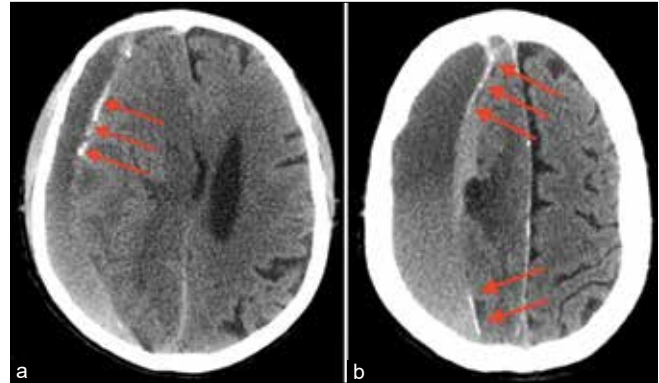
Head computed tomography (CT) scans of patient 1 after MMA embolization. (a) Axial plane, level of lateral ventricles; (b) axial plane, level of centrum semiovale. Note large right-sided cSDH with enhanced capsule (arrows).
